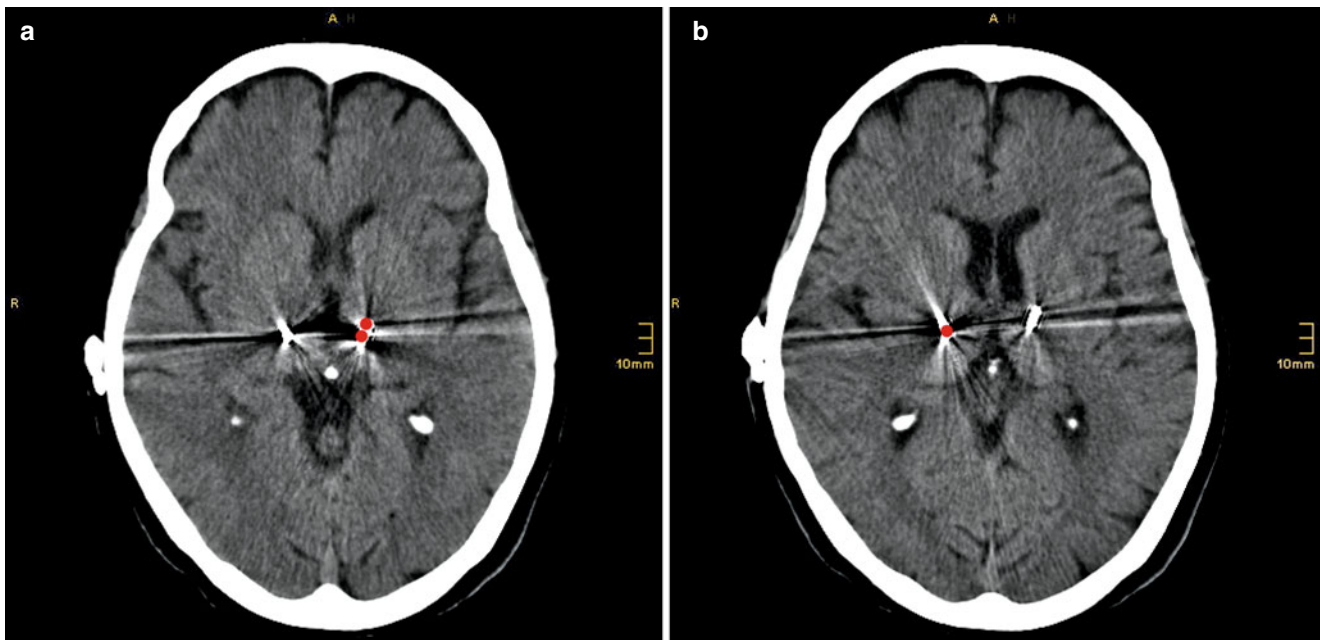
Transversal slices of the computed tomography of this patient with red circles indicating the stimulated contacts. (a) Transversal slice in plane with the AC-PC-line. (b) Transversal slice 3 mm dorsal to the AC-PC-line
